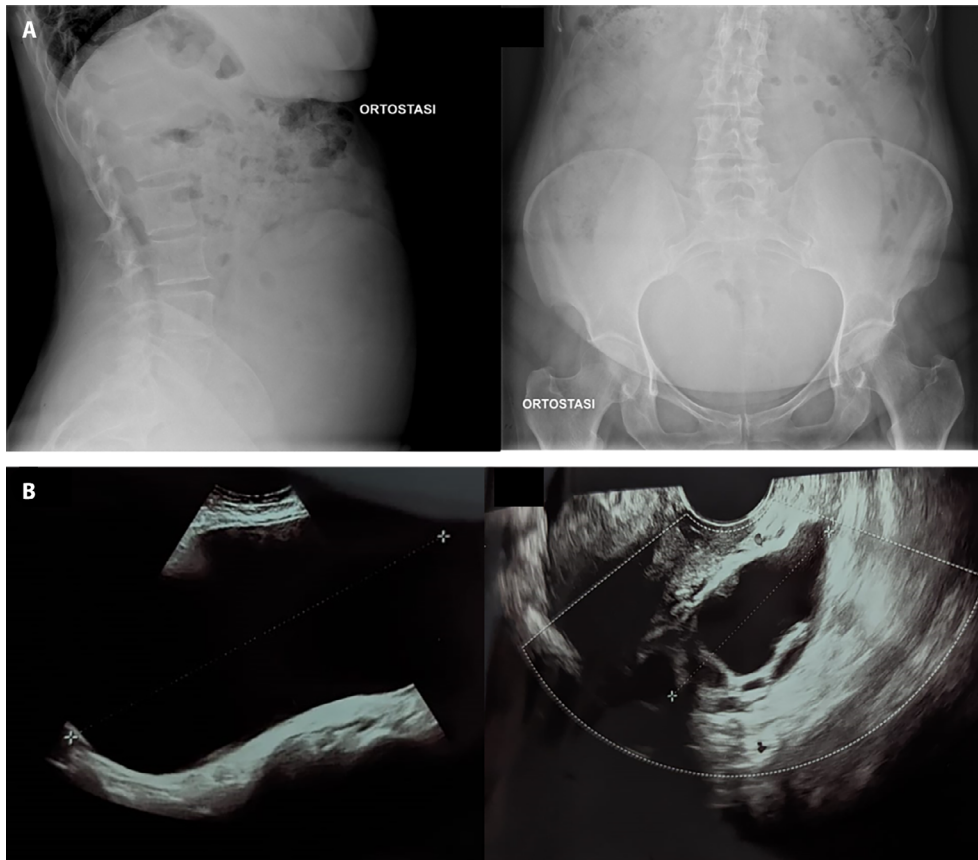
First imaging approach with plain X-ray of the abdomen (A) and Ultrasound (B). In (A) both in the lateral and anteroposterior film, there was evidence of a voluminous radio-opacity with well-defined margins in the mid-abdomen and the pelvis. In (B) the pelvic ultrasound showed an anechoic formation with a cystic appearance of considerable size, to be better evaluated with further diagnostic exams; the transvaginal ultrasound showed a cystic lesion of the left ovary, multiloculated due to the presence of septa, with a solid hypoechoic, non-vascularized tank.
